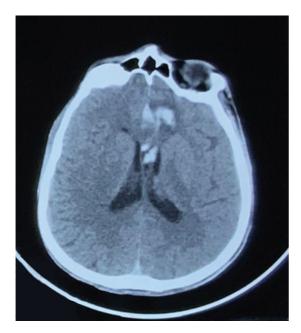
Head computed tomography showing subarachnoid hemorrhage with blood in the anterior interhemispheric fissure.
